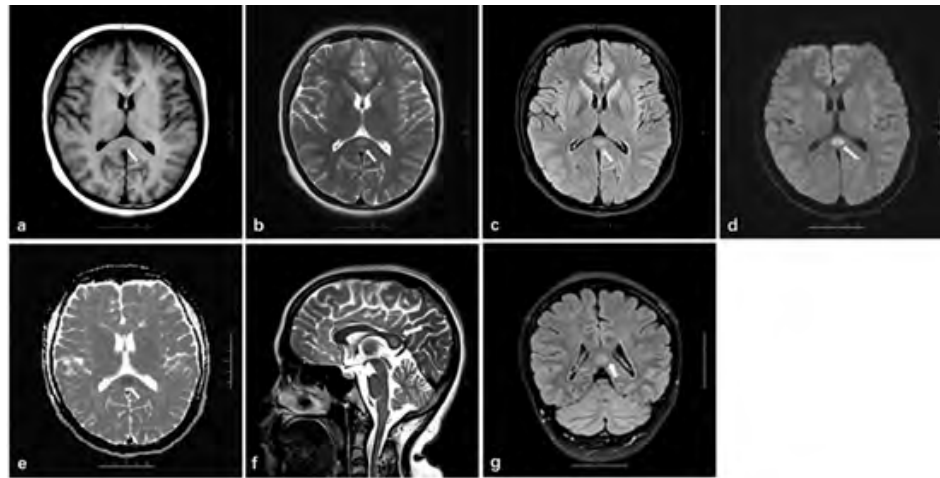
MRI showed an isolated oval lesion in the SCC (arrows) with slight hypointense on T1WI (b), slight hyperintense on T2WI (a) and T2-FLAIR (c), hyperintense on DWI (d), decreased ADC values (e), the sagittal (f) and coronal (g) T2-FLAIR showed the same lesion. MRI, magnetic resonance imaging; SCC, splenium of the corpus callosum; T1WI, T1-weighted imaging; FLAIR, fluid attenuated inversion recovery; DWI, diffusion weighted imaging; ADC, apparent diffusion coefficient.
